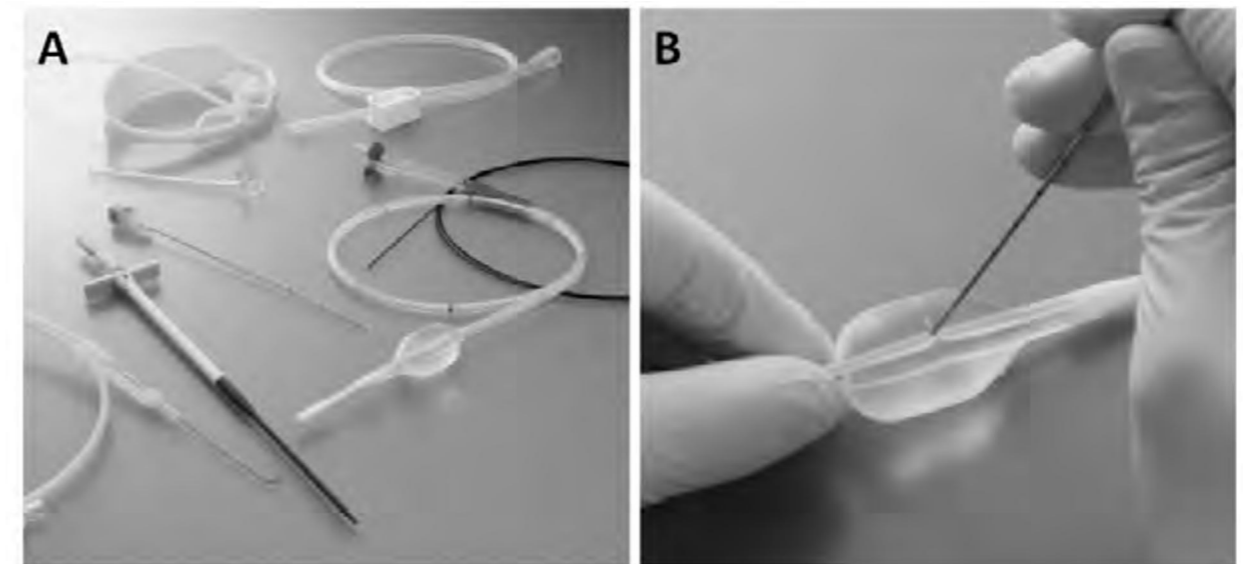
A) A percutaneous transesophageal gastro-tubing kit
